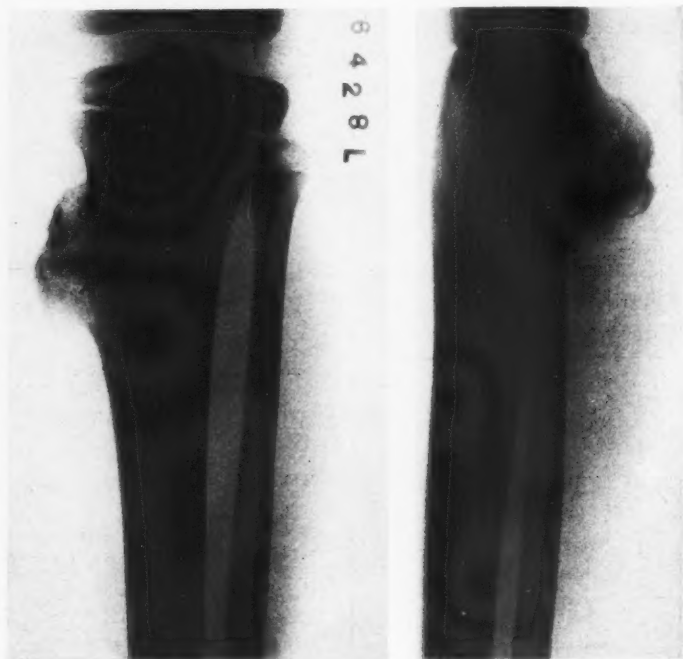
Roentgenogram of a typical benign exostosis of the upper tibia. The normal bone bulges out to meet the neoplastic cartilaginous cap and forms a base or pedicle for the growth. Lines of calcification are present in the cartilaginous portion.*
